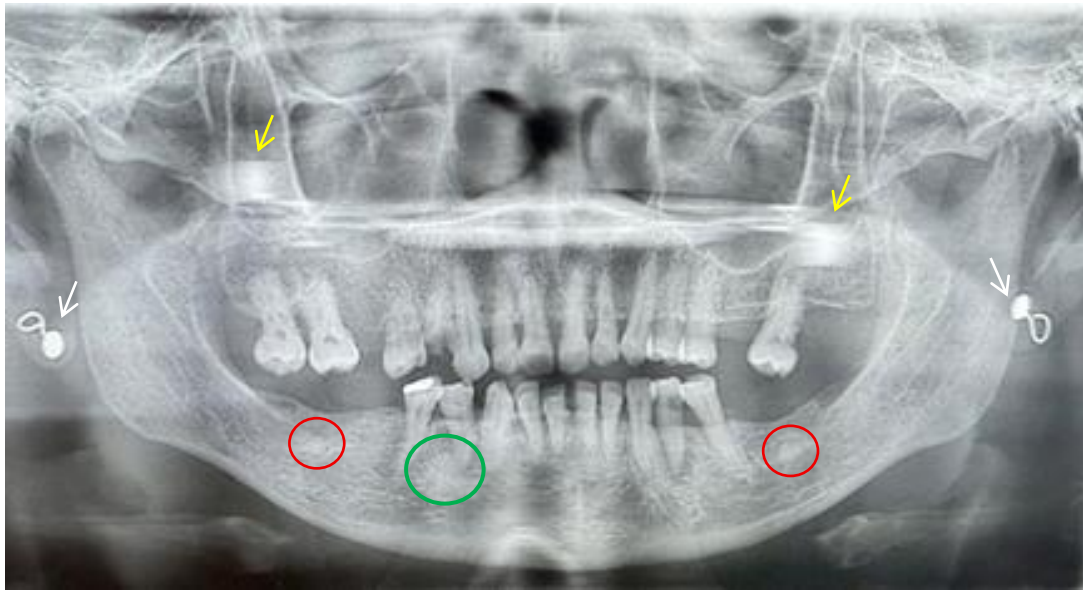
Panoramic radiograph showing well-defined radiopaque lesions in the edentulous regions of teeth 37 and 47 (red circles) consistent with Type III Dense Bone Island, and another radiopaque lesion in the apical area of 44 (green circle), presenting as a Type IV Dense Bone Island.
